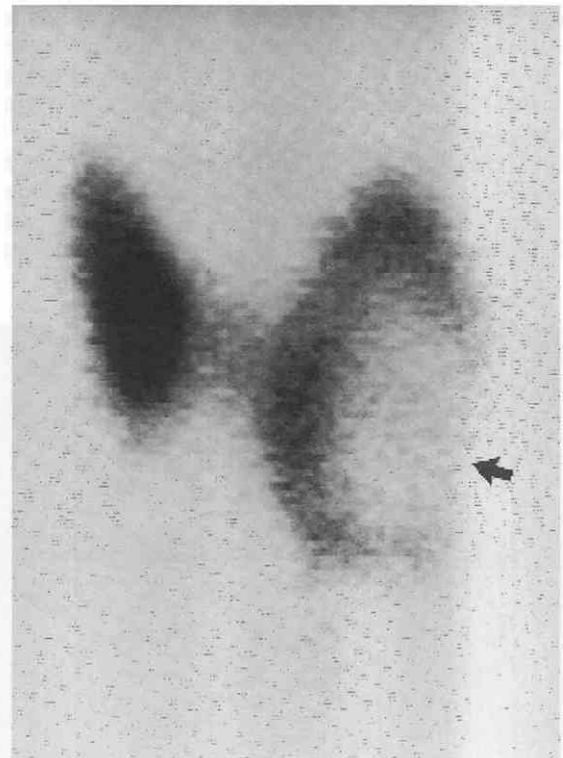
An anterior view obtained during technetium 99m-pertechnetate scintigraphy shows a large solitary hypofunctioning nodule (*arrow*) in the lower pole of the left thyroid lobe. The nodule was subsequently resected and found to represent a papillary carcinoma. The right thyroid lobe is normal.
